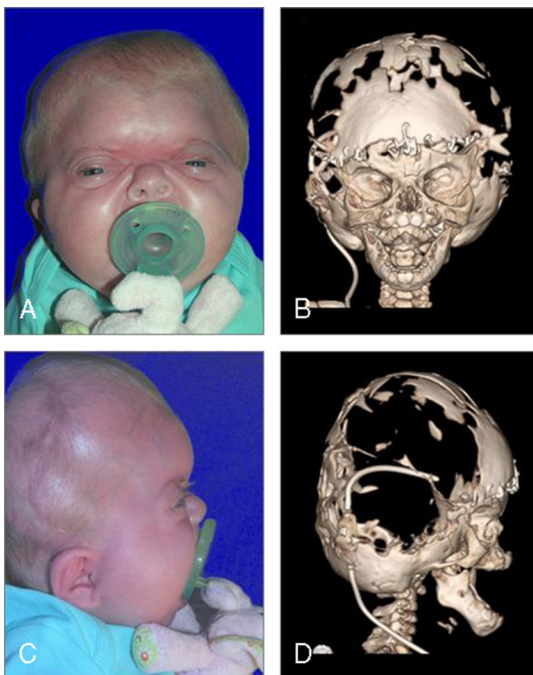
Postoperative photographs (A, C) and 3-dimensional computed tomographic scans (B, D) 5 months after decompression, reconstruction, and distraction.
